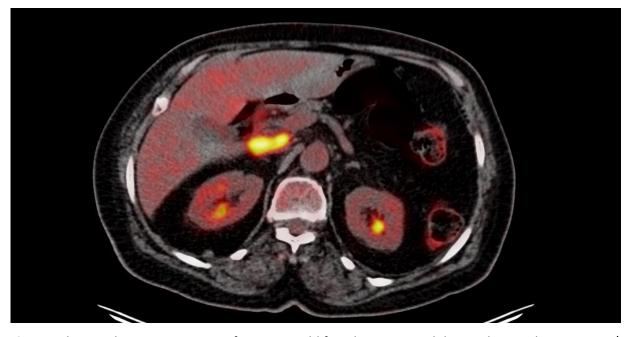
In the initial staging purposes of a 72-year-old female patient with known lung malignancy, PET/CT imaging showed a hypermetabolic mass lesion at the head of the pancreas that was suspicious for metastasis, and the biopsy result was compatible with benign mature lymphoid tissue.
